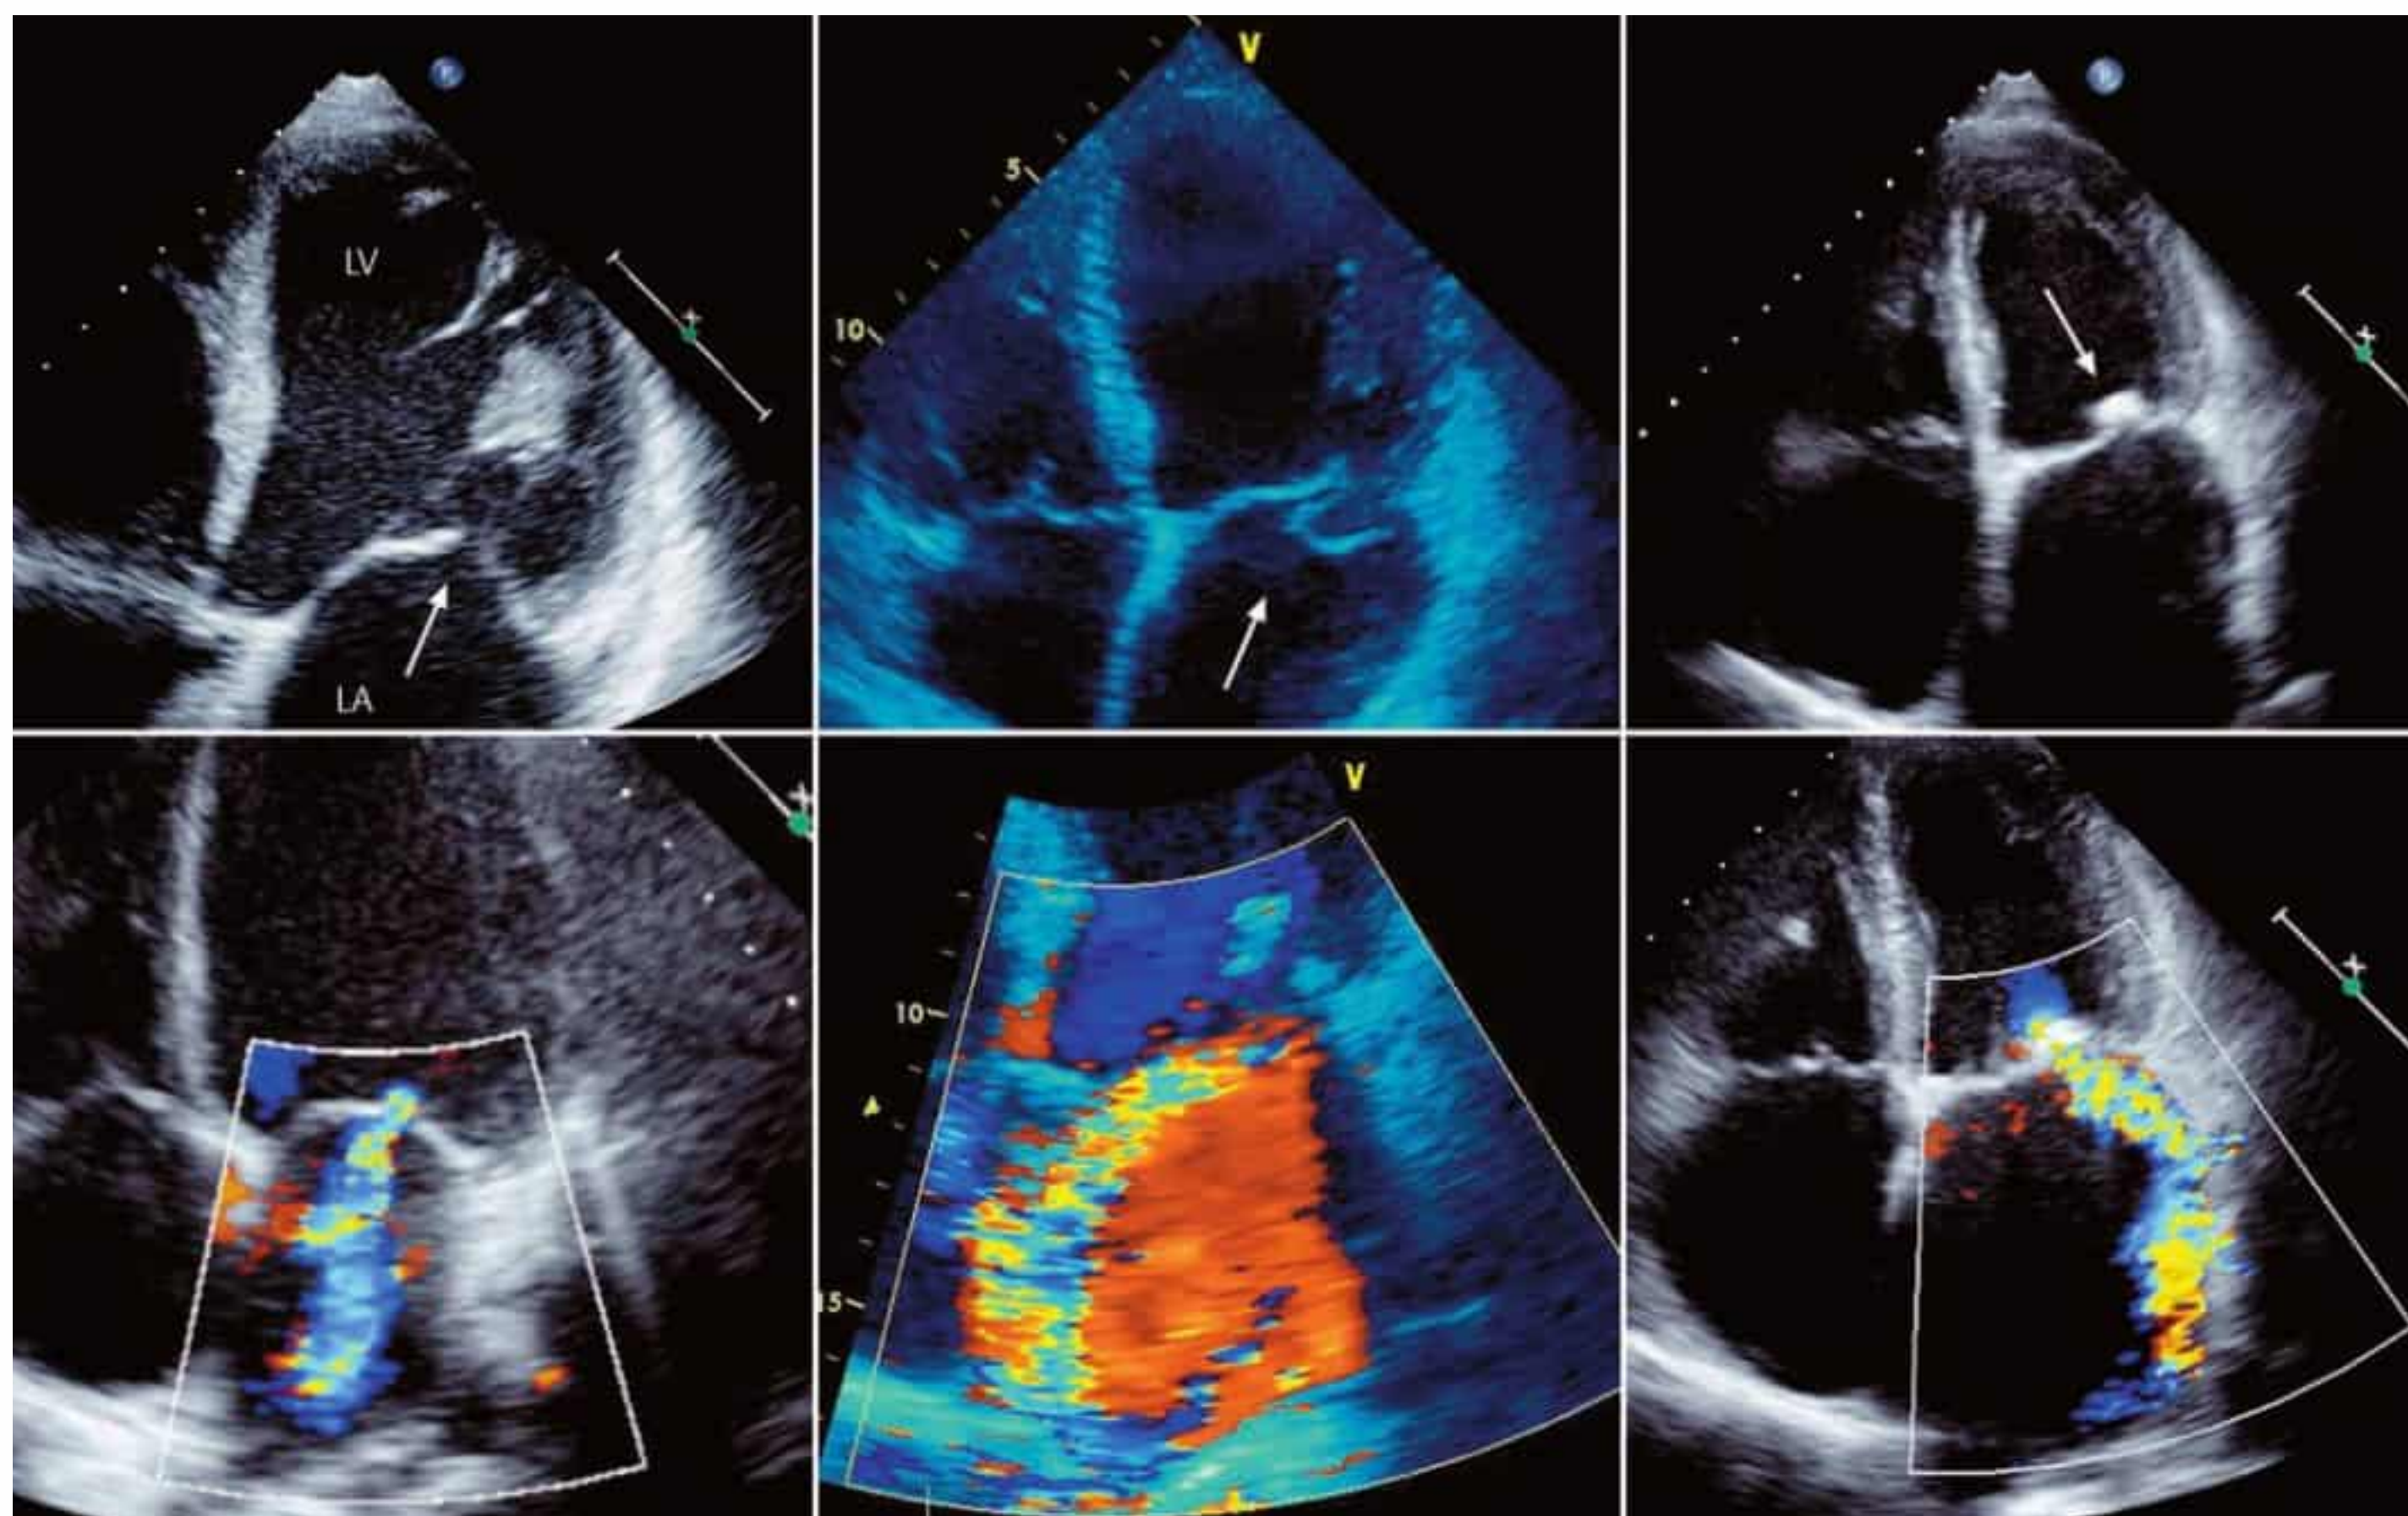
Echocardiographic comparison of different etiologies of mitral insufficiency. Left: functional mitral insufficiency with typical tethering of the mitral leaflets, incomplete valve closure (top, arrow), and a central jet visible on color Doppler (bottom). Center: prolapse of the posterior mitral valve leaflet
